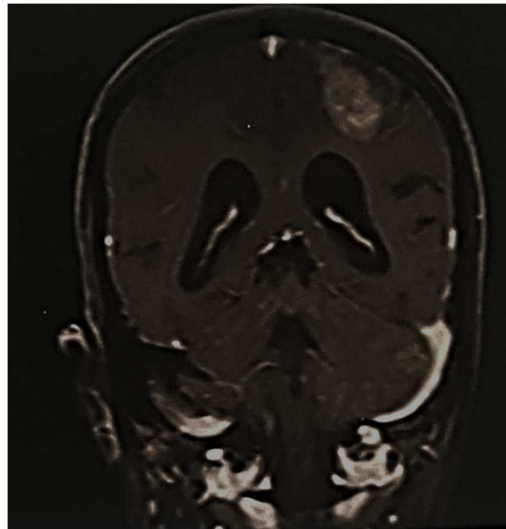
MRI SHOWING LOW GRADE GLIOMA – CORONAL T2 WEIGHTED IMAGE SHOWING AN ILL DEFINED T2 HYPERINTENSITY
